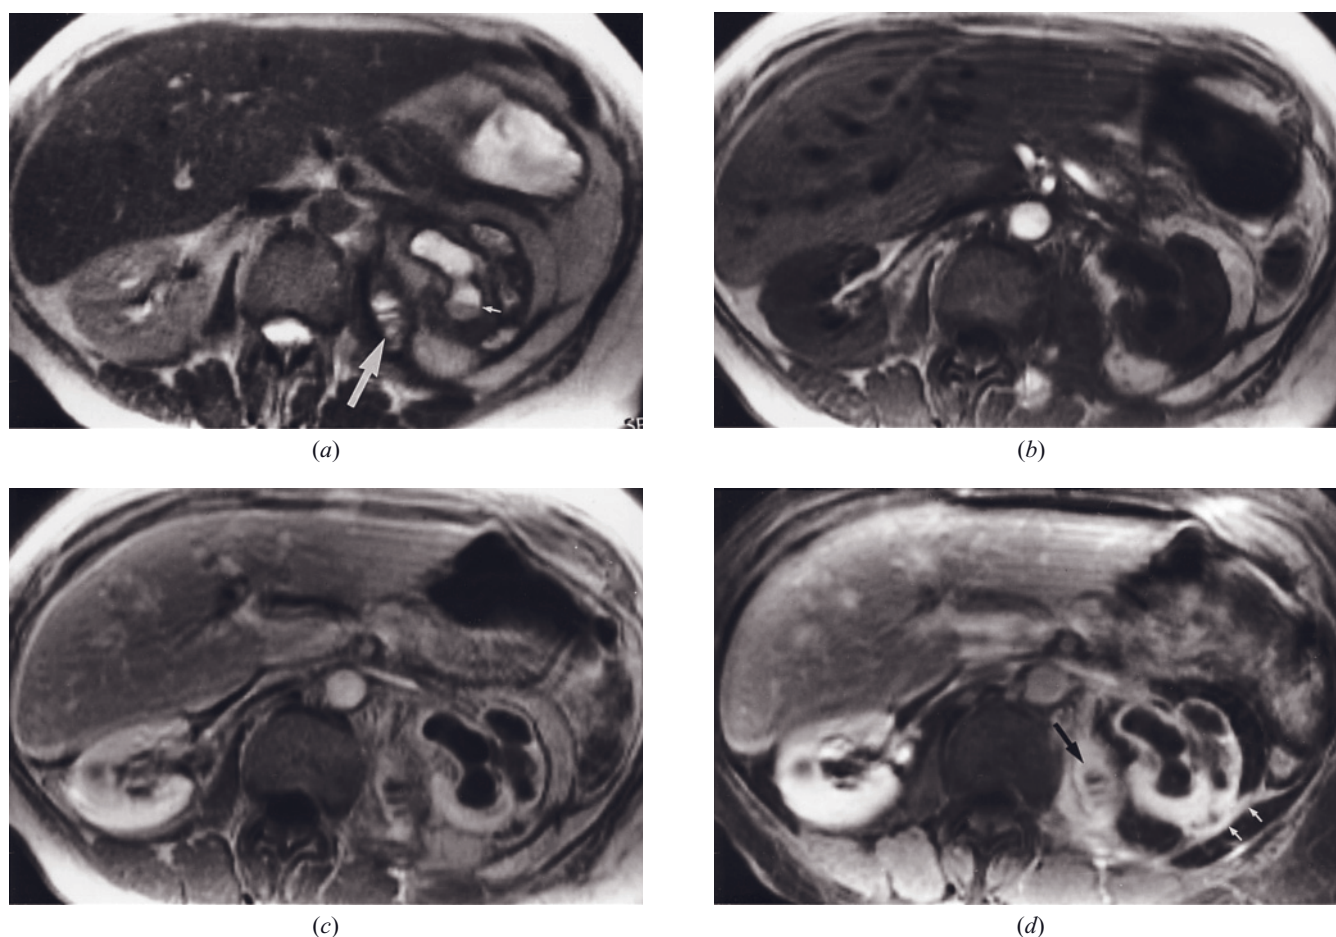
Xanthogranulomatous pyelonephritis. T2-weighted SS-ETSE (a) and T1-weighted precontrast (b) and 90-s (c) and 4-min fat-suppressed (d) postgadolinium SGE images. The left renal collecting system is noted to be dilated (a–d). A large extrarenal component of the infection is noted in the psoas muscle (arrows, a, d). Layering of low-signal-intensity material (small arrow, a) is noted in calyces on the T2-weighted image. No excretion of gadolinium by the involved kidney is apparent on the 4-min postgadolinium image. Inflammatory changes in Gerota fascia and lateral conal fascia (small arrows, d) and psoas abscess are most clearly defined on the gadolinium-enhanced fat-suppressed image. Dilatation of the collecting system, lack of contrast excretion, and prominent extrarenal inflammatory changes are features observed in xanthogranulomatous pyelonephritis.
